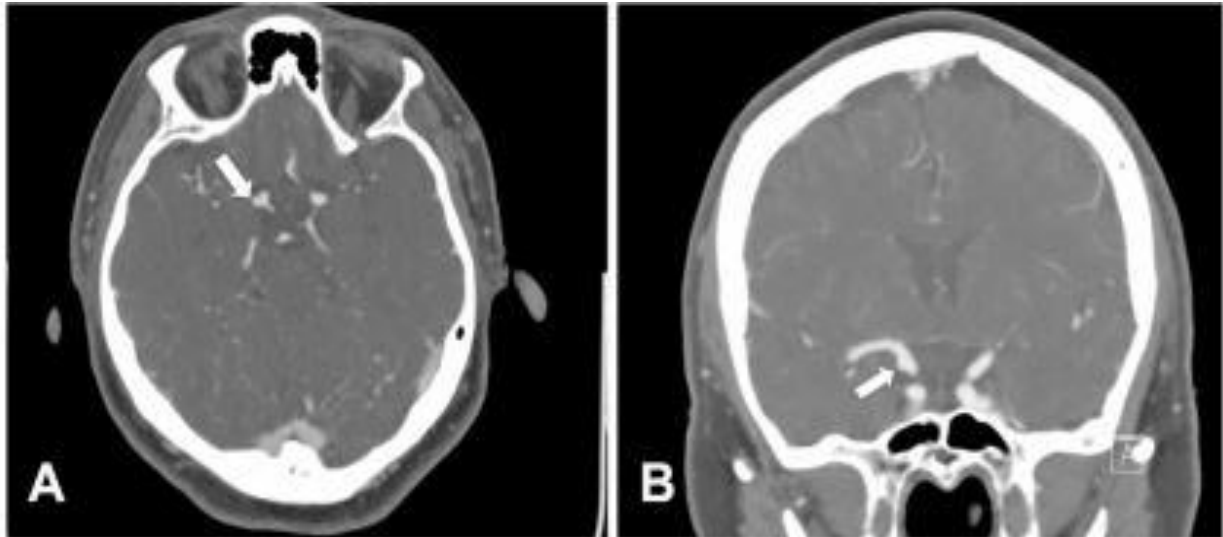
a) Axial CT angiogram demonstrating 3-mm blister aneurysm (arrow). b) Coronal CT angiogram reconstruction of the aneurysm (arrow)
